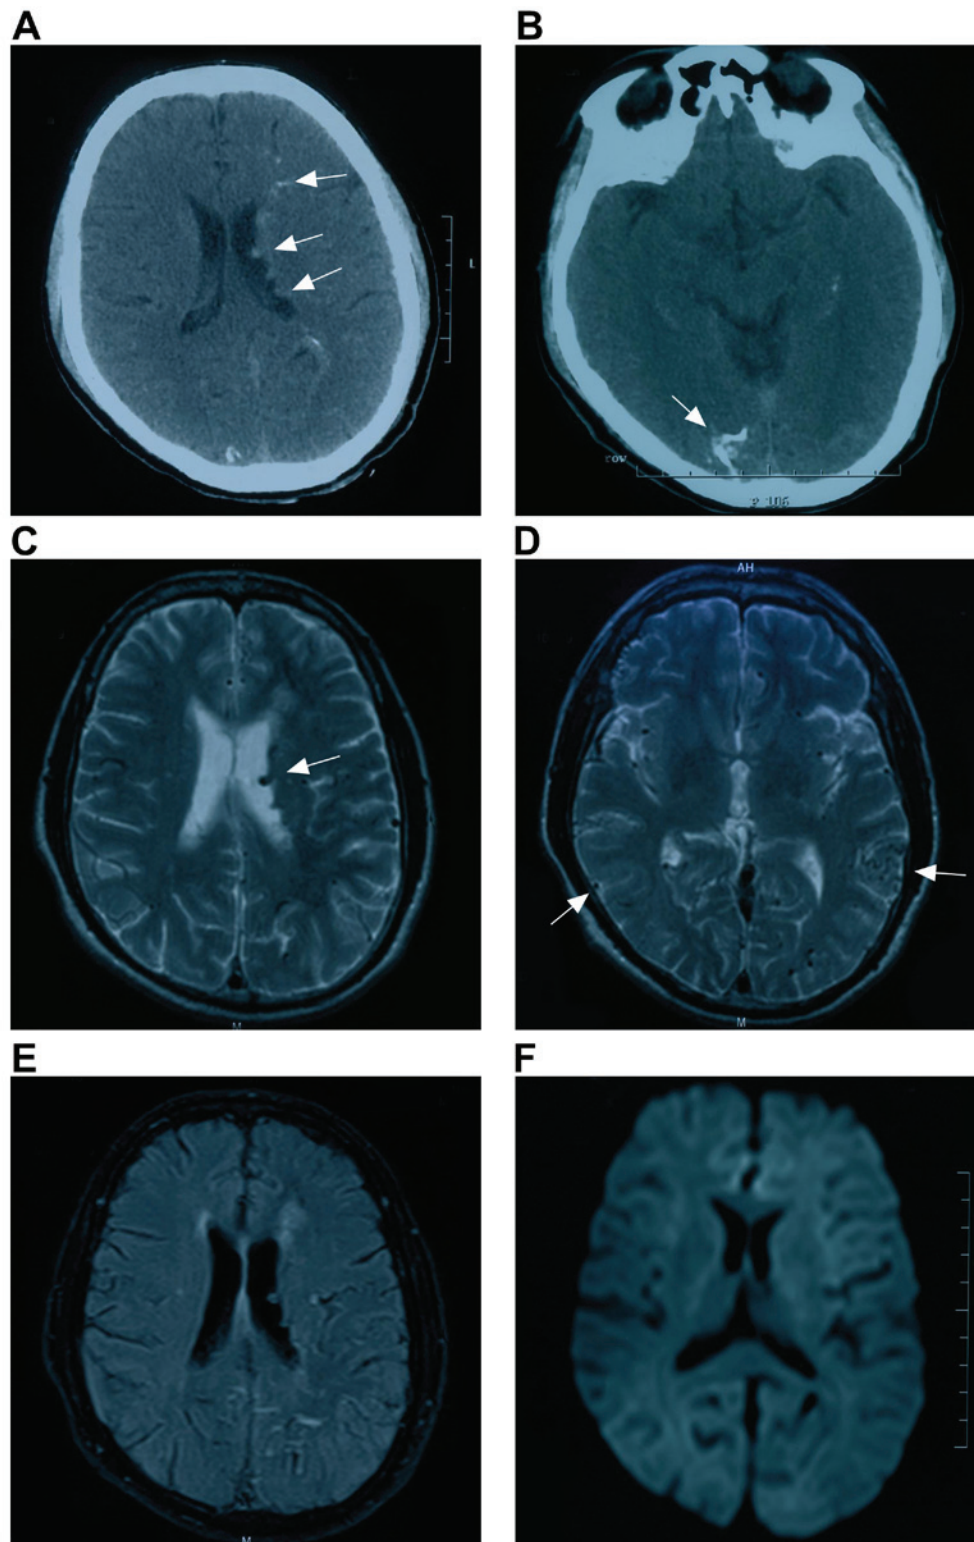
Brain CT and MRI images. Representative images from a patient admitted to the First Hospital of Jilin University (Changchun, China) in May 2015 presenting with multiple dural arteriovenous fistulas are shown. All images were reproduced with the consent of the patient. (A and B) CT detected multiple high-density lesions that were considered as calcification lesions in the (A) lateral ventricle and (B) tentorium (white arrows). (C and D) Axial MRI of T2 weighted images identified dilated vessels in the (C) lateral ventricle and (D) brain surface (white arrows); (E) axial MRI of a fluid-attenuated inversion recovery image identified no infarction; (F) axial MRI of a diffusion-weighted image also identified no infarction. CT, computed tomography; MRI, magnetic resonance imaging.
